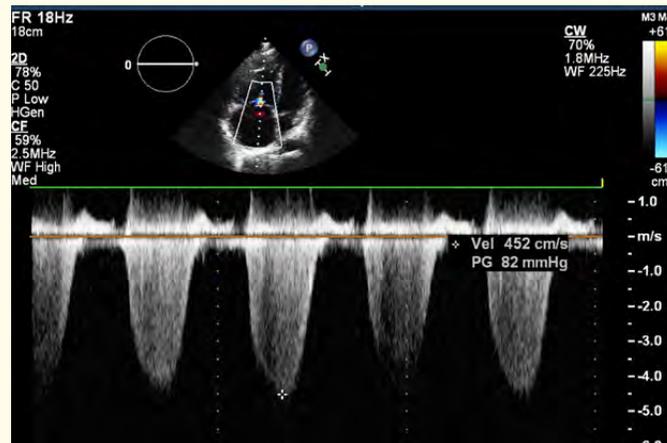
Continuous wave Doppler tracing across the jet of tricuspid valve regurgitation. The estimated systolic PAP can be derived to be around 95.0-100.0 mmHg.
